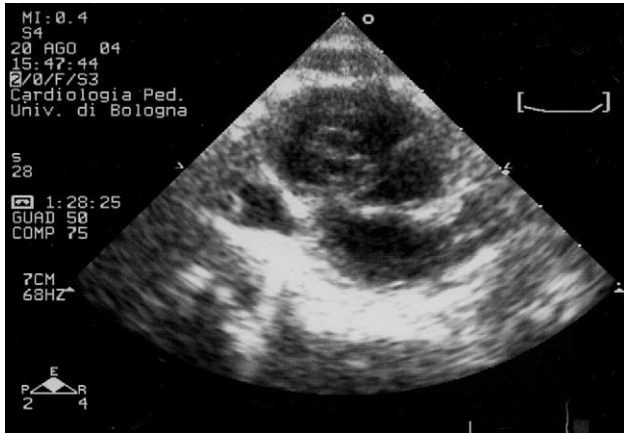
Two-dimensional echocardiogram in parasternal short axis view shows the two orifices of the tricuspid valve during diastole.
